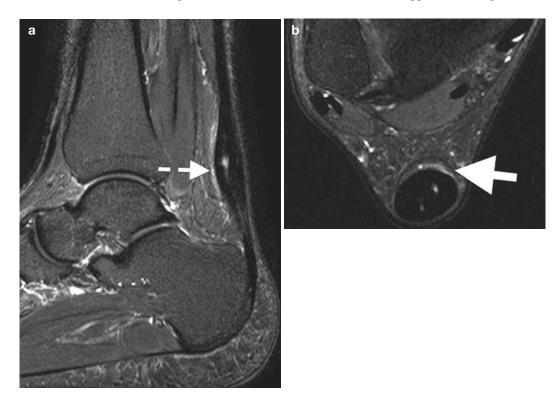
MRI of a tendinotic Achilles tendon: (a) Sag and (b) axial T2FS of a thickened mid-tendon with interstitial tear and anterior margin rim of high signal intensity (*dashed arrow*) of the paratenon in keeping with peritendinitis
